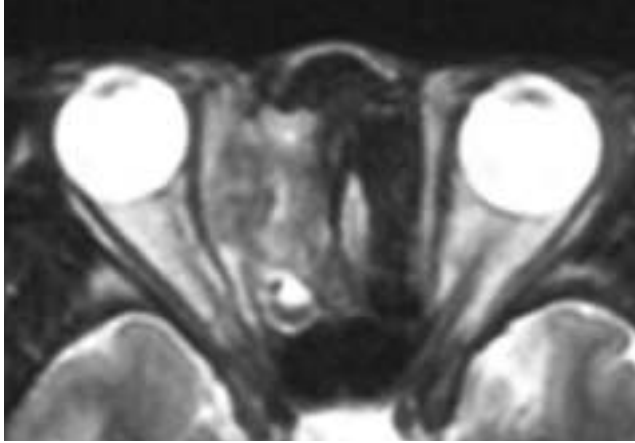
T2-weighted MR image shows slight high signal intensity soft tissue adjacent muscles.
